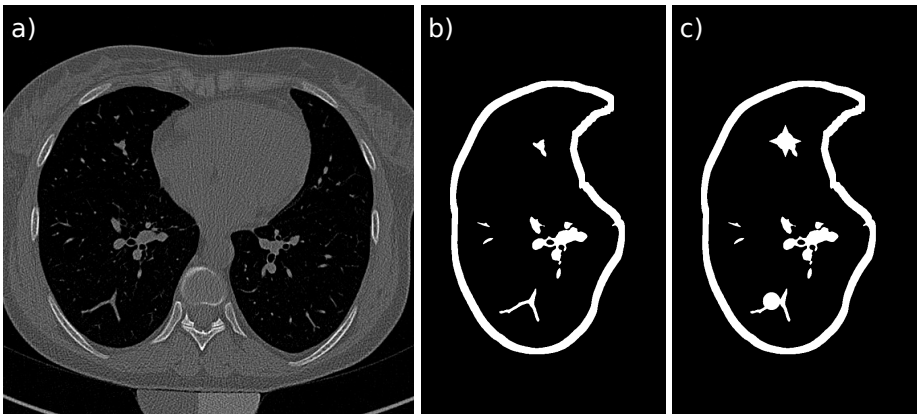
CT of the lungs and segmentation of the right lung.
